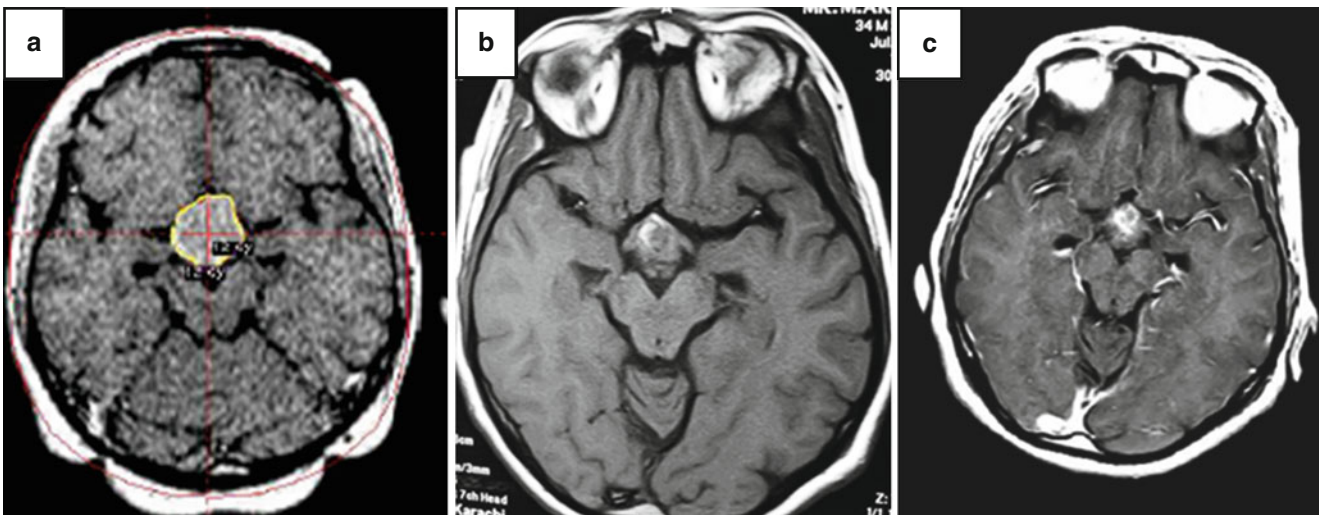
Contrast-enhanced T1-weighted MRI of a 32-year-old man with a solid craniopharyngioma treated with subtotal resection and subsequent GKS. (a) At the time of radiosurgery, the volume of the residual tumor was 7.2 cm³ and 12 Gy marginal dose was applied to the 50 %
